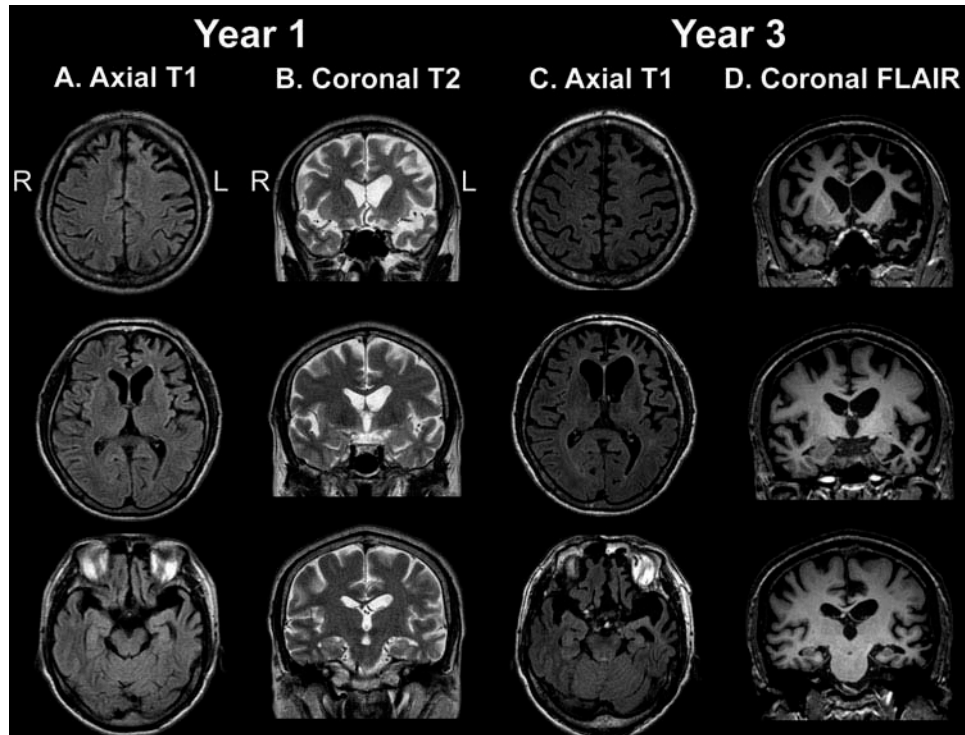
Brain MR images of patient J. K. at Year 1 (A and B) and Year 3 (C and D): In Year 1 (age 59), brain MR images reveal mild atrophy in the bilateral dorsolateral and medial frontal cortex. The larger anterior horn of the left lateral ventricle is suggestive of greater atrophy in the left frontal lobe than the right. Anterior temporal atrophy was also noted with the left being more prominent than the right, which was further supported by the greater temporal horn atrophy in the left than that of the right (A and B). Brain MR images in Year 3 (age 61) show more marked atrophy in the bilateral anterior temporal areas as well as dorsolateral and medial frontal lobes with the left being more severe than the right. Atrophy in the left insula and anterior temporal lobe (predominantly involving the left temporal pole) worsened in comparison with the MR images acquired in Year 1 (C and D).
